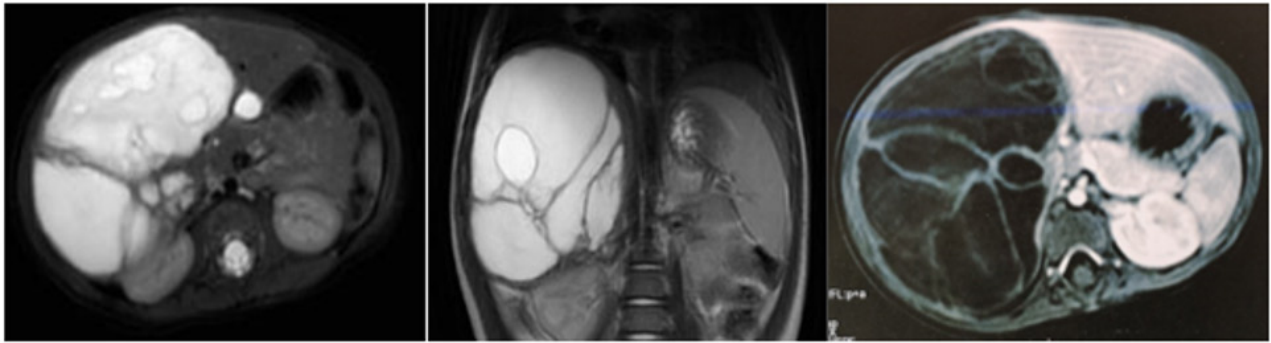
A. Abdominal CT scan showed a heterogeneous mass of the liver (segments V, VI, VII and VIII). Multiple partitions enhanced by the contrast agent, oval with regular contours and sharp limits measuring 95X66X100 mm, compression the hepatic veins, the portal vein and the right kidney.
